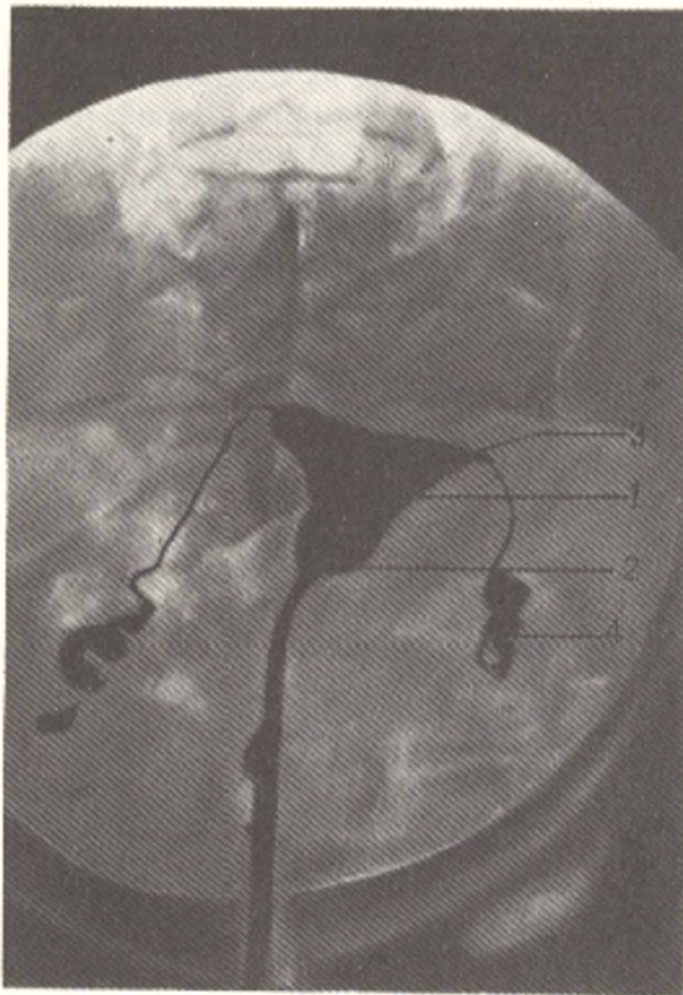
Radiograph of uterus and oviducts.
